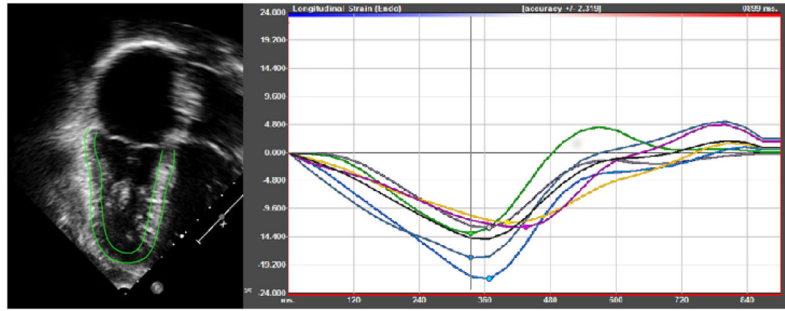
This figure demonstrates the endocardial and epicardial tracing when performing speckle-tracking echocardiography and the resultant strain waveforms after analysis.
